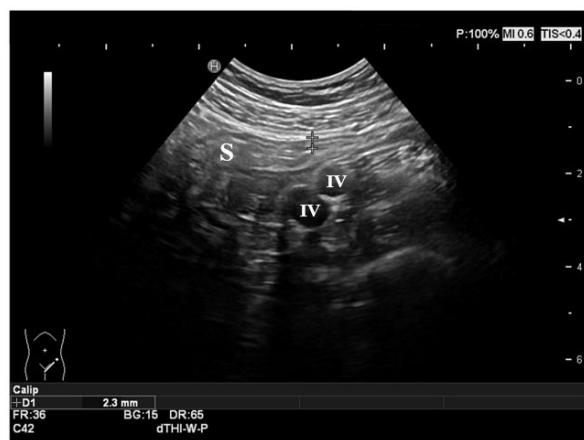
Normal ultrasonographic features of the gut. The sigmoid colon is shown in the figure, with normal thickness and stratification of the layers. The iliac vessels represent the anatomic landmark in the left iliac fossa. S: sigmoid colon; IV: iliac vessels.
